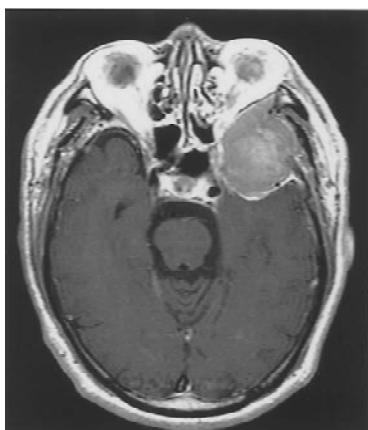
Magnetic resonance imaging demonstrates 3 cm mass in left orbit.
